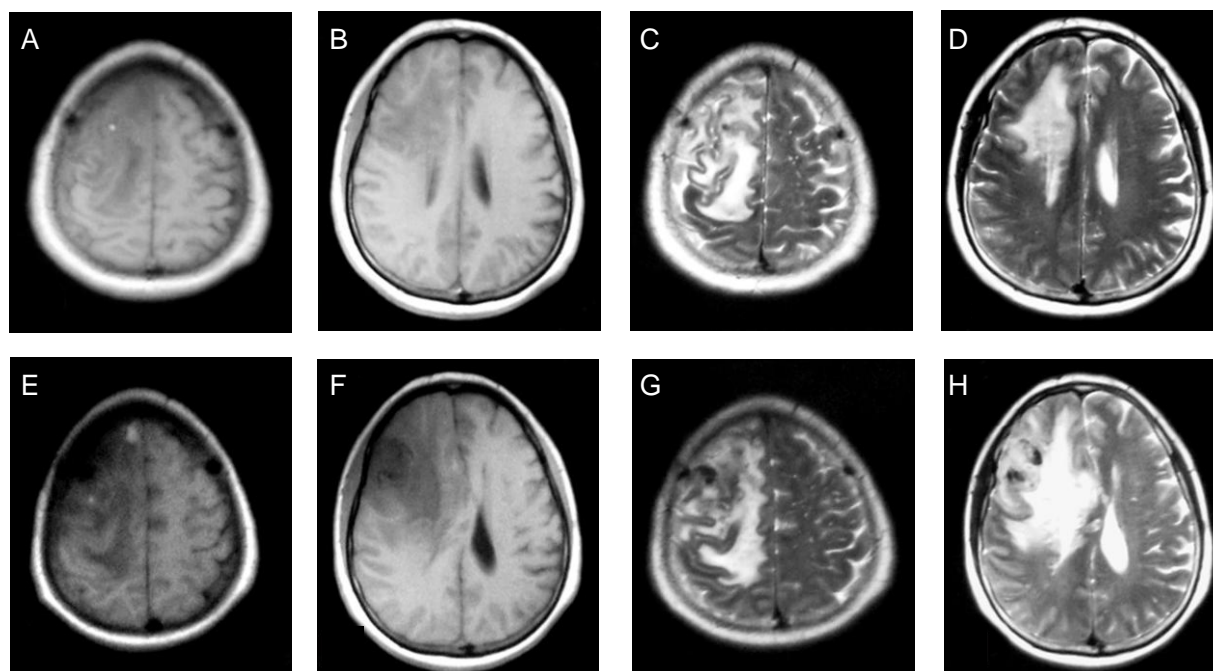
Brain MRI of a patient with isolated cortical vein thrombosis.
